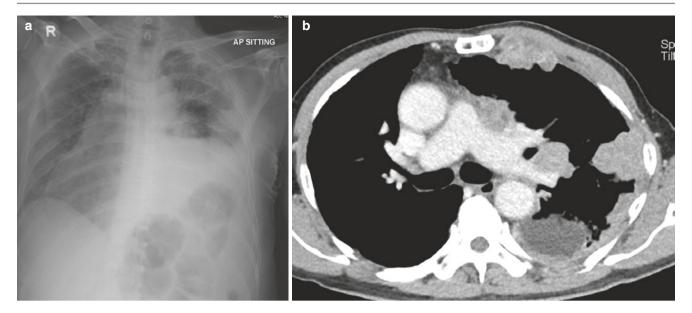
Mesothelioma in a 55-year-old male patient. (a) Frontal chest radiograph shows volume loss in the left hemithorax, nodular peripheral left-sided opacities encasing the left lung. (b) Axial CT
